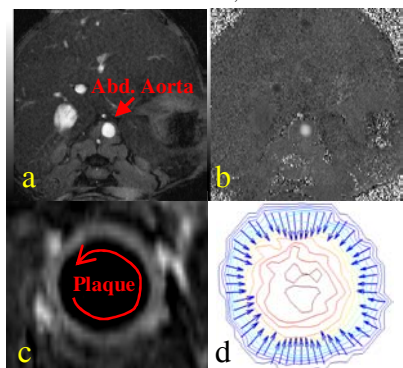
Velocity field map and wall shear stress distribution. (a) MR image of abdominal aorta; (b) velocity map; (c) high resolution plaque image; (d) shear stress distribution and velocity contour.
